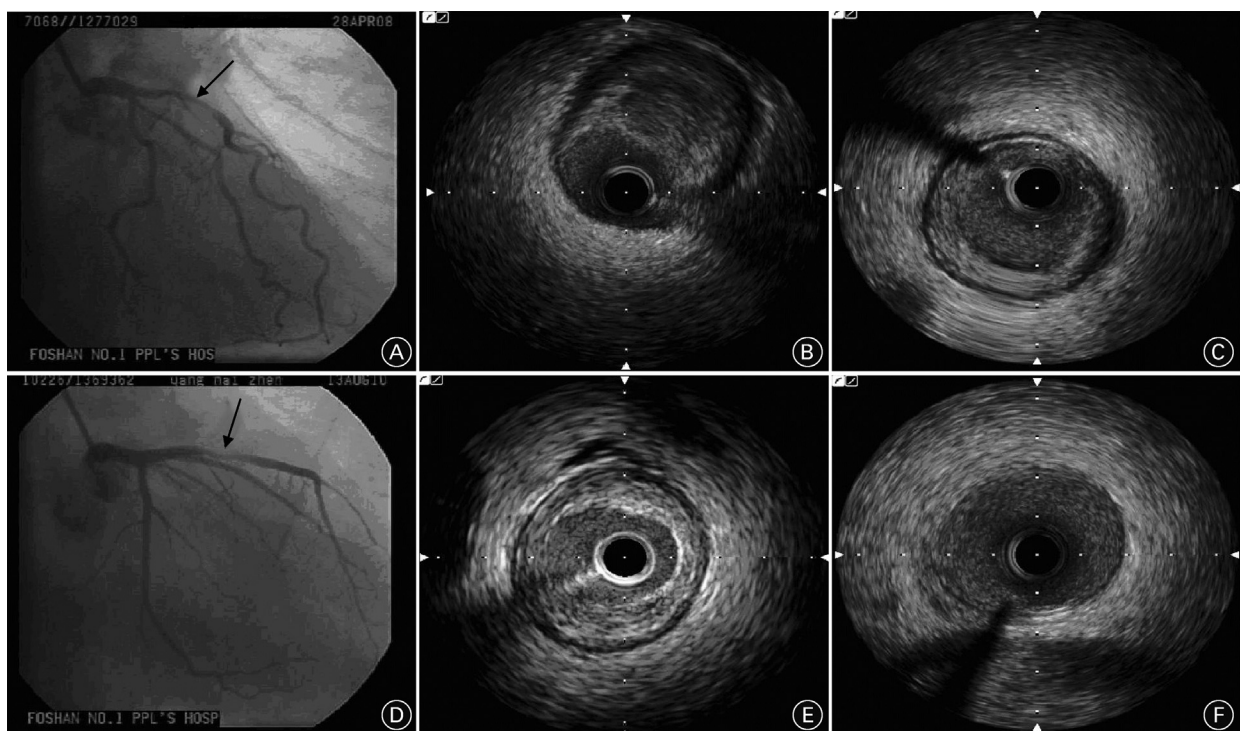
Angiographic and intravascular ultrasound (IVUS) images from the impaired glucose tolerance (IGT) Group (top) and the normal blood glucose (NBG) Group (bottom). a: The proximal end of the left anterior descending artery (LAD) in the IGT group had eccentric 60% stenosis. b: IVUS image of the IGT Group showing that the proximal end of the LAD had eccentric and soft plaque (10-3 spots); the lumen area was 4.48 mm<sup>2</sup> and the rate of area stenosis was 68.14%. c: a reference vessel in the IGT Group. NBG Images: d: The proximal end of the LAD in the NBG Group had 50% stenosis. e: IVUS image of the NBG Group showing centralized, fibrous plaque; minimal lumen area was 6.04 mm<sup>2</sup> and the rate of area stenosis was 52.31%. f: a reference vessel in the NBG Group.
